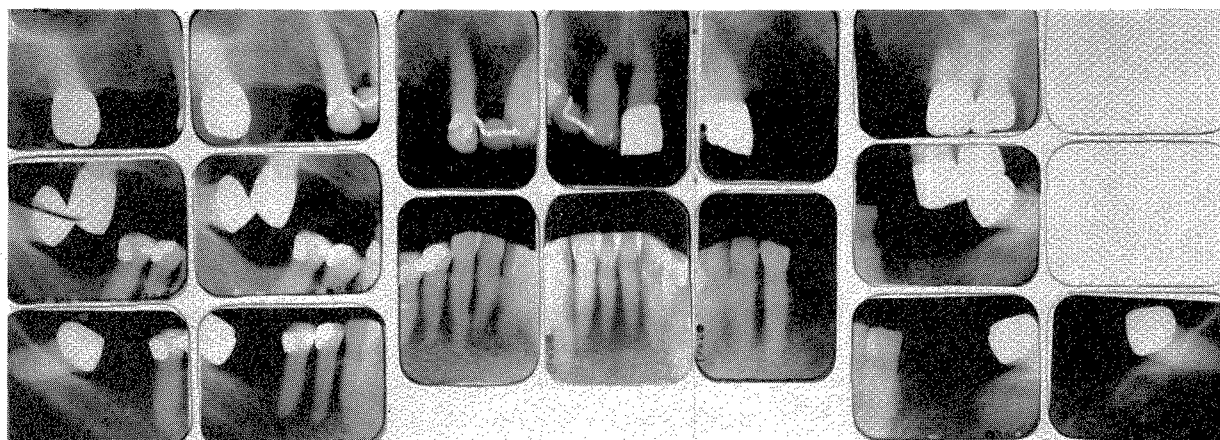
Roentgenograms taken twenty-five years after work was completed (1962).
